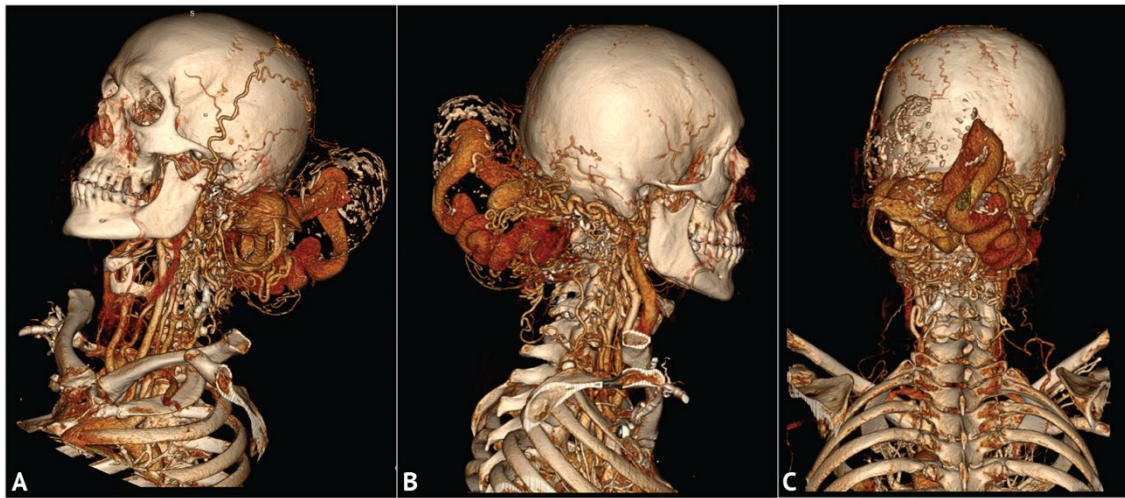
Different projections of 3D CT angiogram after endovascular stages (A–C)
